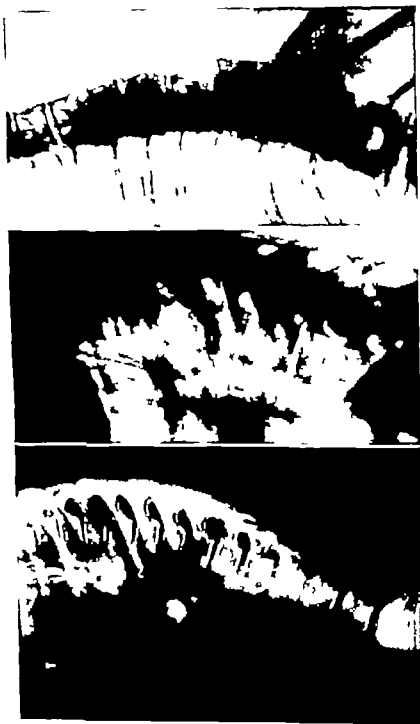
Roentgenograms of normal and scoliotic spines. A Lateral view of normal spine outlines of vertebral bodies regular and sharply defined. Intervertebral spaces clear. Epiphyses visible anteriorly as thickening. B Scoliosis. Lateral view of normal spine showing so called vertebral epiphyses in early stage. Outlines of vertebral bodies irregular and indistinct. Intervertebral spaces diminished in size and irregular (involved vertebrae between arrows). C Anteroposterior view showing scoliotic spino secondary to vertebral epiphyses. B and C are of same patient.
